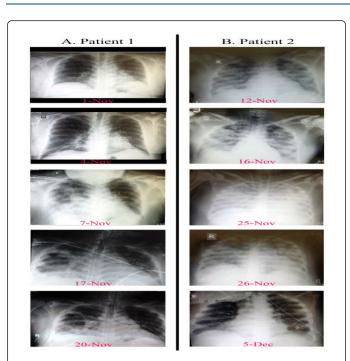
Panel A shows chest radiography performed for patient 1. The first radiograph was done for the patient in the Accidents and Emergencies department on the day of his arrival from Saudi Arabia. The second radiograph, performed three days later in the Accidents and Emergencies department, shows more apparent right lower lobe involvement. The third radiograph was taken on the day of admission showing marked progression of the infection. Panel B shows chest radiography performed for patient 2. After the addition of ribavirin, marked bilateral reduction of the consolidation could be seen by comparing the radiographs taken on November 25 and November 26. Almost complete clearance of the opacification was achieved by December 5.
